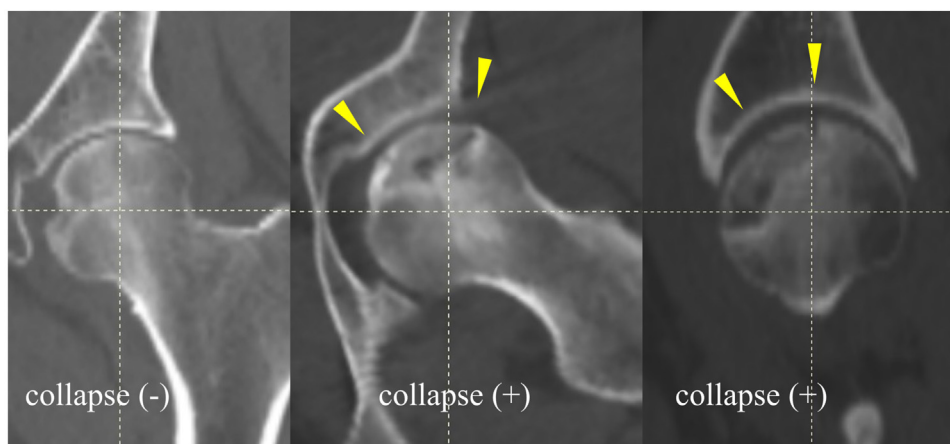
The presence of collapse, defined as step-off, flattening, and breaching of the articular surface, was determined in the reconstructed frontal plane, which included the femoral head center on the computed tomography scan image.
